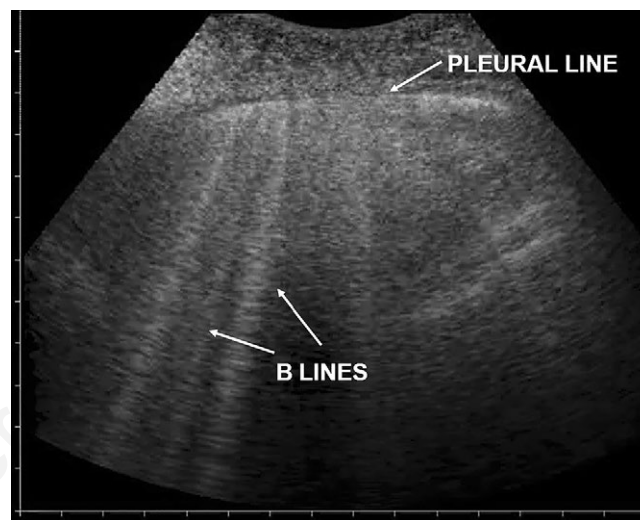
Lung ultrasound showing B lines indicating pulmonary congestion.
